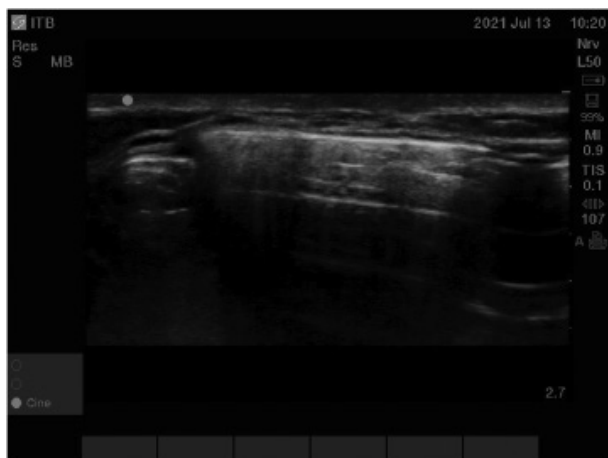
Ultrasound view of a drug delivery device, Medtronic II, which is commonly used in pediatric spasticity management in North America with the side port identified on the left side of the screen (smaller and on the edge of the drug delivery device), while in the midportion of the drug delivery device (right side of image) is the access to the drug reservoir.
